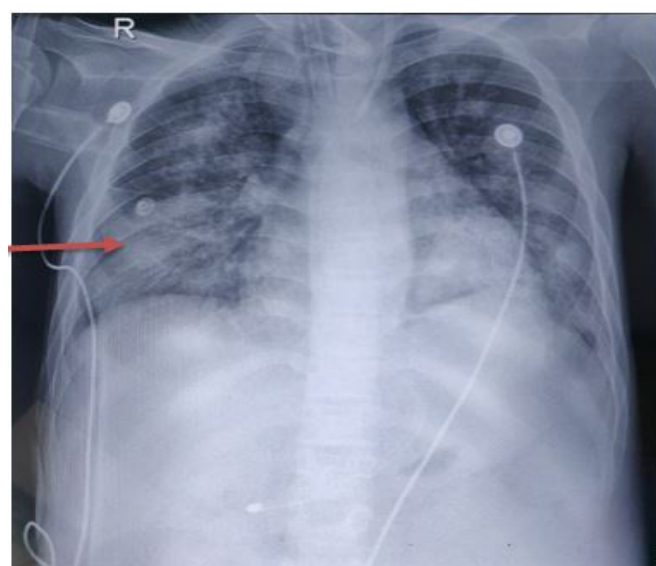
chest x-ray anteroposterior view showing bilateral lung heterogeneous infiltrates.
